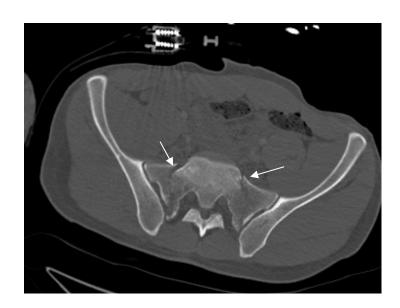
Mounted Casualties. Case Study 2 CT scan (axial view) demonstrating bilateral sacral fractures. Pelvic binder is in place.
